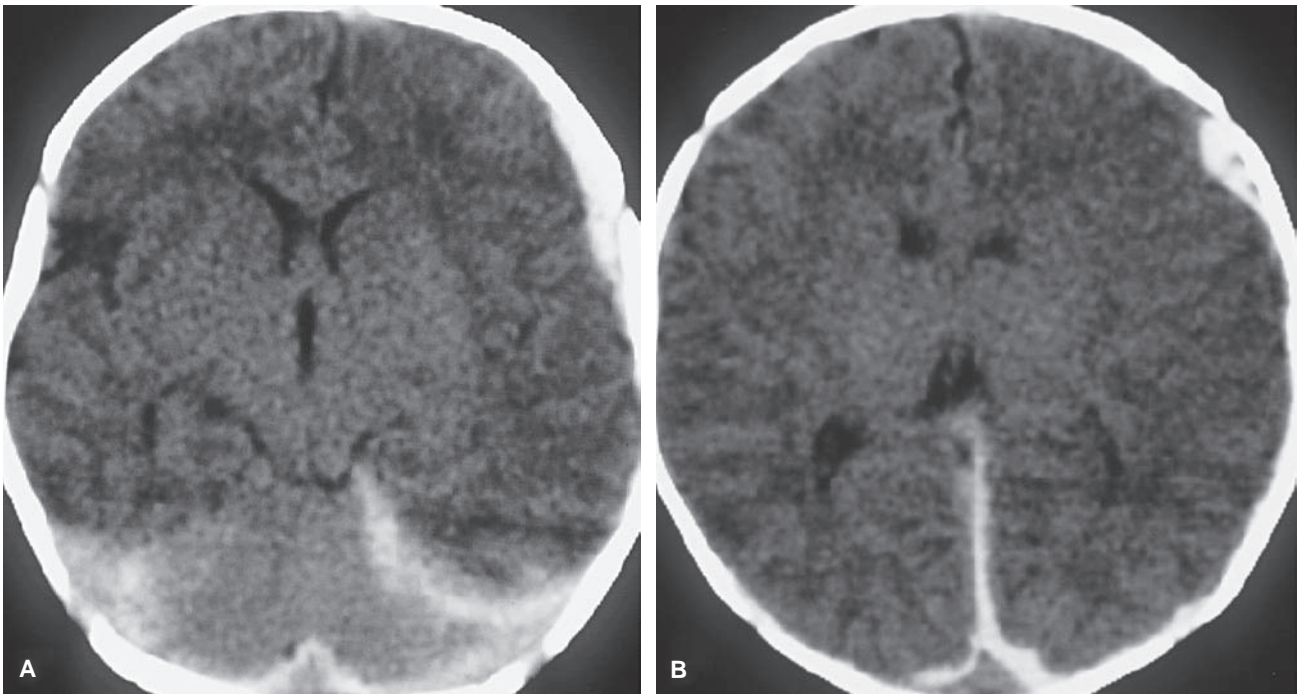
Subdural hematoma. This 14-day-old patient presented with a complaint of lethargy and vomiting. There was no history of trauma. This head computed tomographic scan shows subdural blood tracking along the tentorium (A), in the interhemispheric fissure (B), and in the left frontoparietal region (A and B). There is also some effacement of the sulci and loss of gray–white differentiation. Child abuse was suspected.
